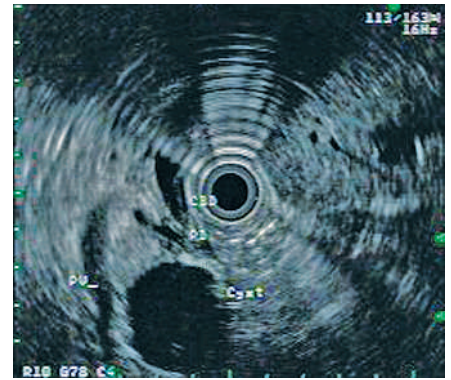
Radial endoscopic ultrasound image from patient 1, showing the cyst in relation to the common bile duct (CBD), pancreatic duct (PD) and portal vein (PV).
